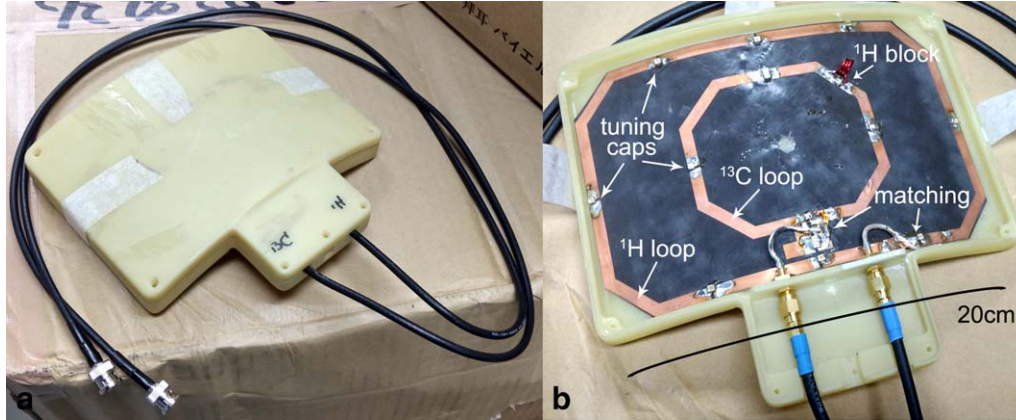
Photographs of custom $^{13}\text{C}/^1\text{H}$ paddle coil used for ^1H -decoupled ^{13}C MRI experiments. a: Coil exterior and cabling. b: Coil internals consisting of concentric octagonal ^1H (inner) and ^{13}C (outer) elements, with key components labeled by arrows.
